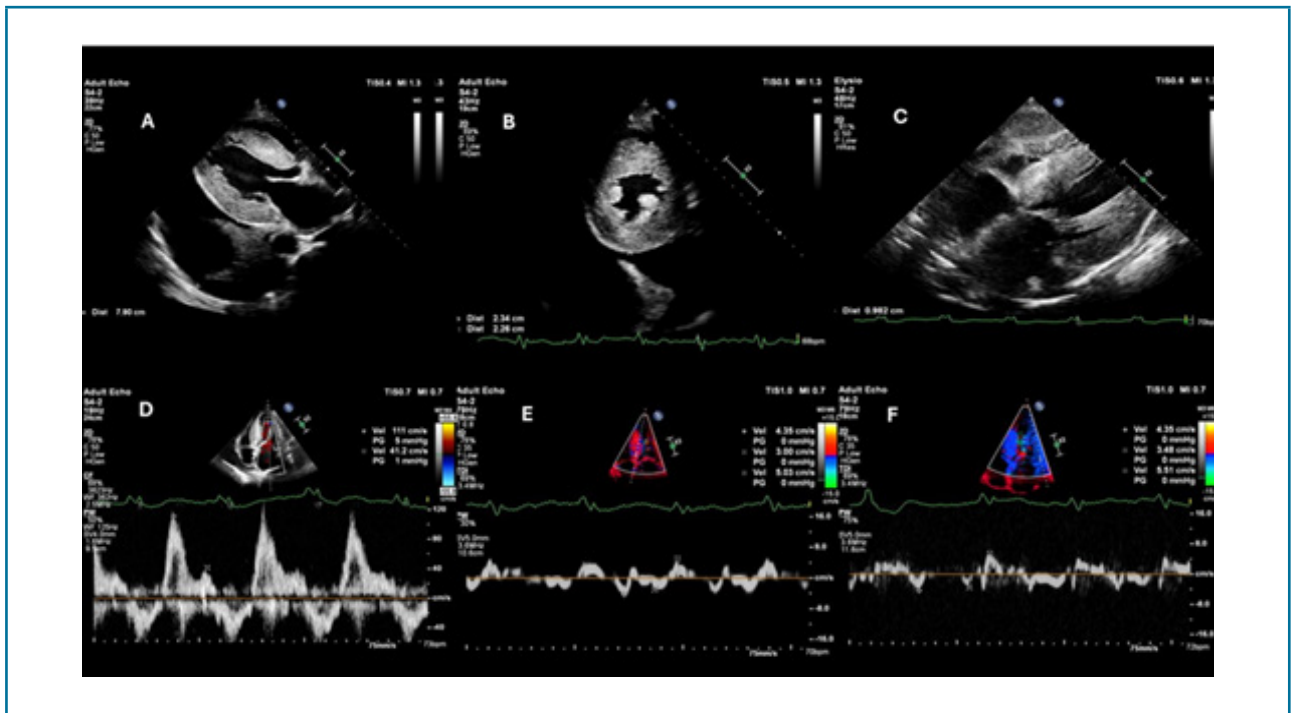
Conventional echocardiographic findings suggestive of CA in a 71-year-old patient with arterial hypertension and previous myocardial revascularization admitted with HFpEF. Increased LV wall thickness (A and B), pleural effusion (A), interatrial septum thickening (c), LV diastolic dysfunction with a restrictive pattern (E/A 2.7, average E/e' 25.8) (D, E, and F) and “triple 5” sign (E). This patient was diagnosed with light chain amyloidosis, confirmed by anatomopathological examination of bone marrow biopsy
